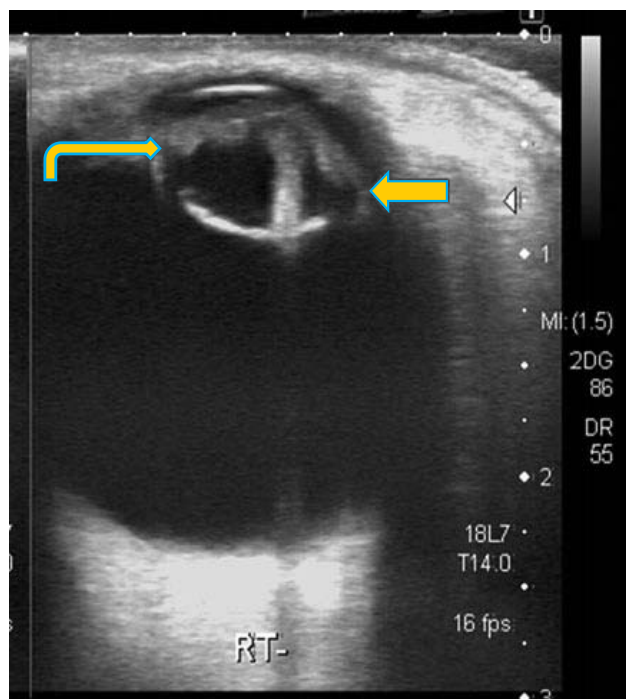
Ultrasound right eye shows linear echogenic foreign body (lead pencil tip) with significant posterior acoustic shadowing. (yellow arrow) Echogenic and thickened lens surface suggestive of cataract changes (curved arrow).
